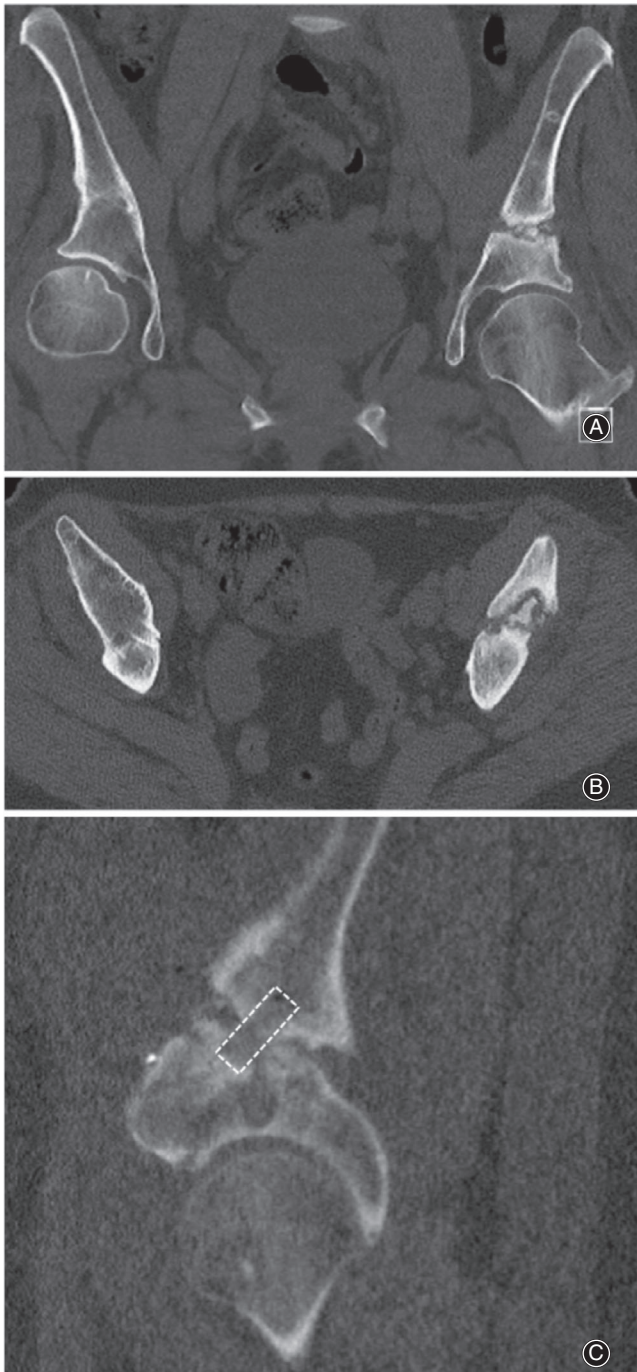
Nonunion of a periacetabular osteotomy (A, B) in a 42-year-old woman. (C) Postoperative computed tomography of the cylindrical bone graft (dashed line) bridging the nonunion.
